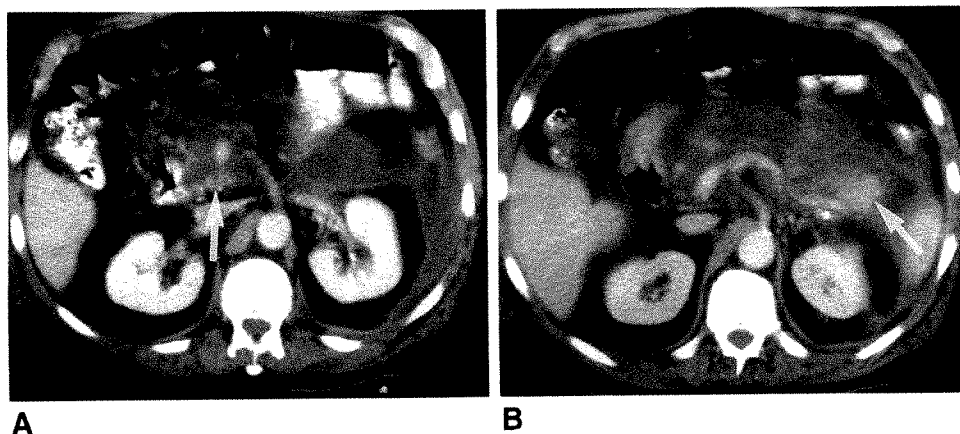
A and B, Necrotizing pancreatitis. Contrast-enhanced CT scan shows nonenhancement of majority of pancreas with enhancement of a small portion of pancreatic head and tail (arrows). These findings of severe necrotizing pancreatitis were confirmed at surgery.
